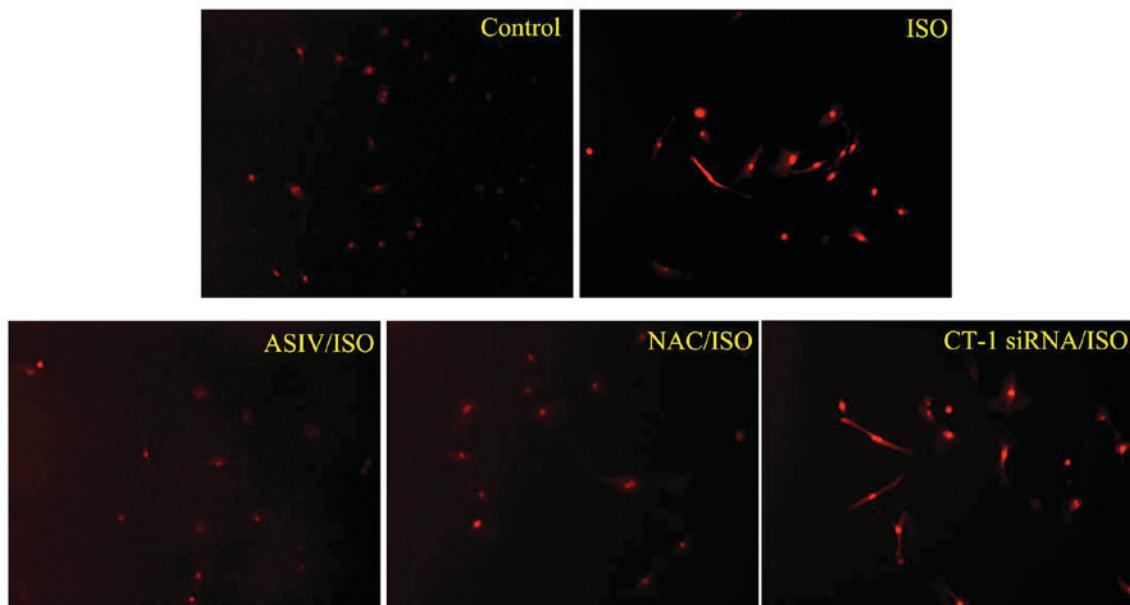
Effect of astragaloside IV (AsIV, 100  $\mu$ M), *N*-acetylcysteine (NAC, 10 mM) and CT-1 siRNA on isoproterenol (ISO, 10  $\mu$ M)-induced reactive oxygen species (ROS) level in cardiotrofoblasts (CFs).
